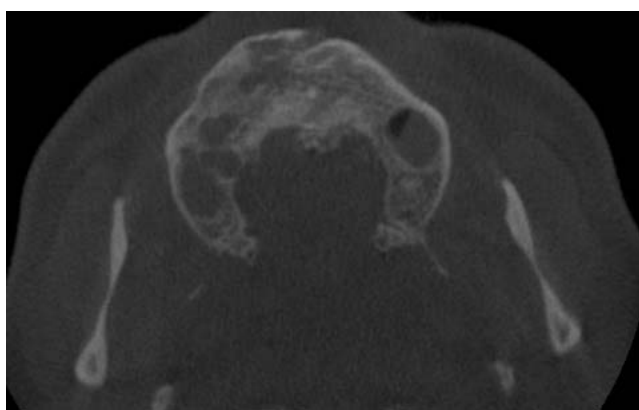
An axial view of the CBCT image shows multiple small cyst-like structures in the right anterior and posterior regions. They are separated by normal bone. The lesion in the molar region is well demarcated, and separated from the maxillary antrum.
